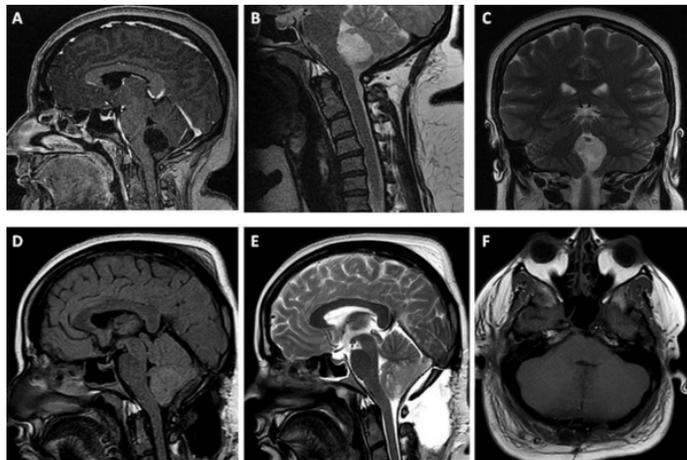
51 years old and male A) Sagittal T1-weighted images showing a fourth ventricle arachnoid cyst during the asymptomatic period B) Hydrocephaly was seen in T2 sagittal, coronal and T1 flair sections after 3 years
